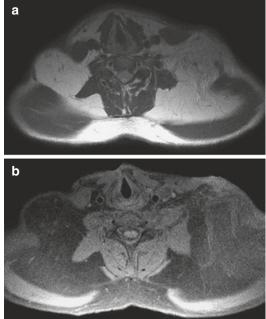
(a, b) Madelung disease in a 53-year-old man with a history of alcohol abuse. (a) Axial SE T1-weighted MR image of the neck. (b) Axial FS SE T1-weighted MR image of the neck. Symmetric fatty deposits under trapezius and sternocleidomastoid muscles and anteriorly in the neck
